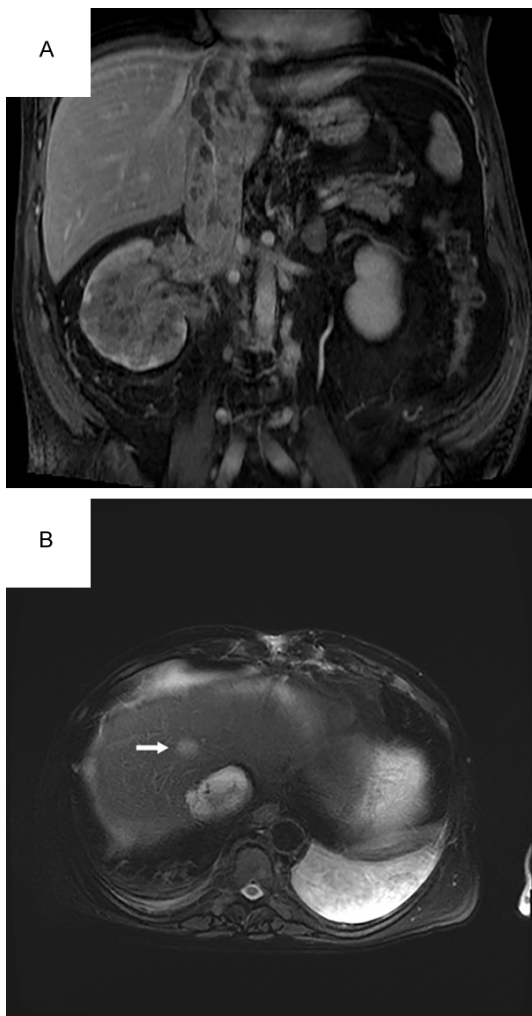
A: Magnetic resonance image (MRI) showing right renal mass, inferior vena cava and right atrium tumor thrombus. B: MRI showing liver metastases of segment VIII (2.1 cm) (white arrow).
